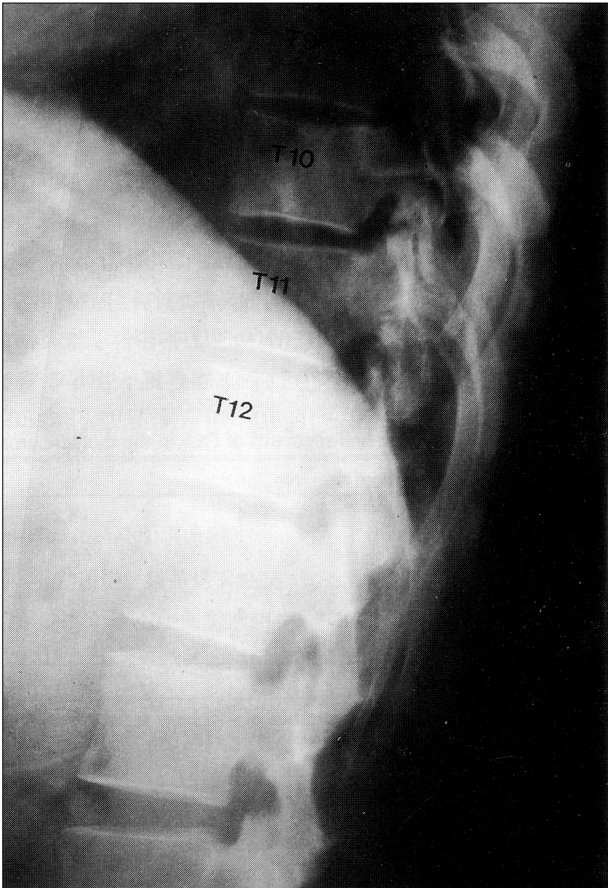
X-ray film showing ossification of the ligamentum flavum in the lower thoracic spine.
